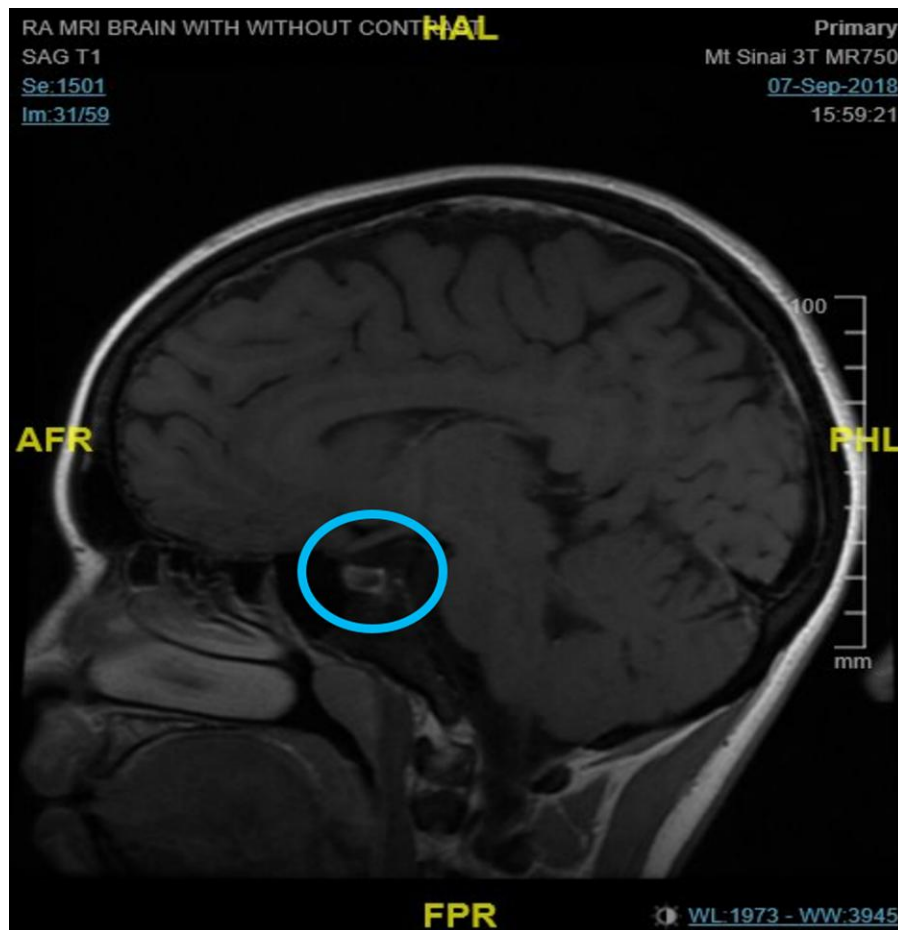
Brain magnetic resonance imaging scan shows a prominent hypointense signal throughout the pituitary gland, suggesting iron deposition in the setting of chronic anemia and recurrent transfusions.
